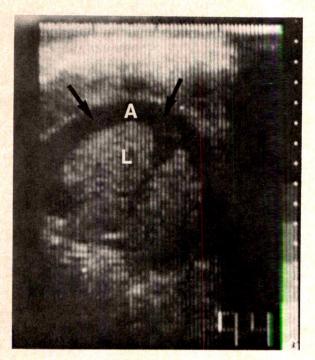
Real-time sonogram showing cross section of hydropic fetal abdomen. *Arrows* point to ascitic fluid (A) outlining enlarged fetal liver (L).
